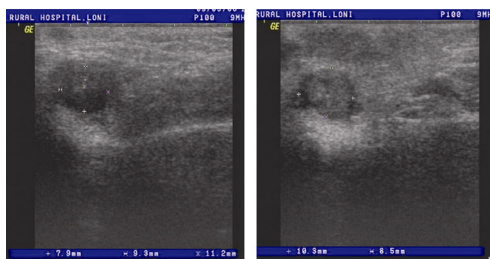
Ultrasonography images.
